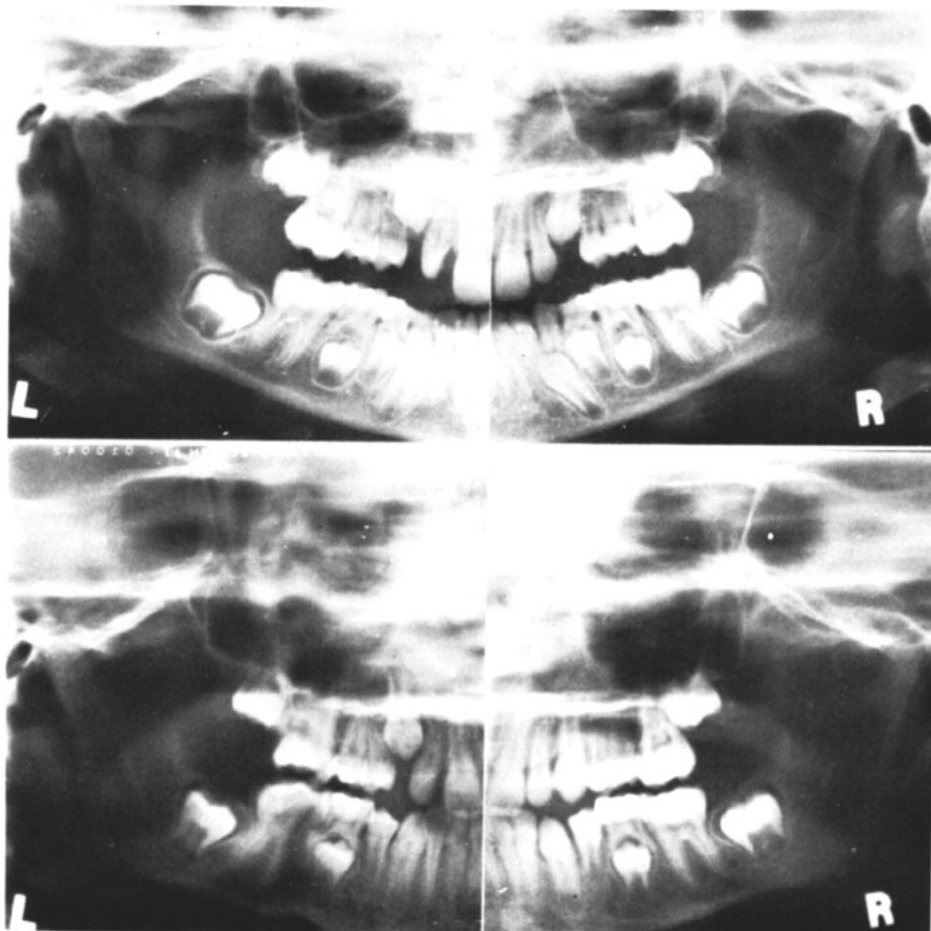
One year comparisons of panoramic X-rays on patient #5 according to Moorrees. Except for teeth unable to erupt, the patient's original 25% retarded dental age responds normally during GHG administration.
